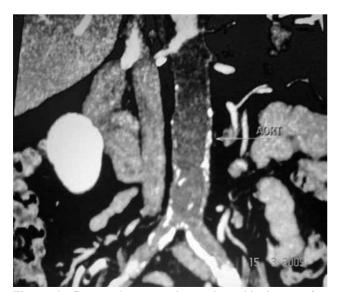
Computed tomography angiographic image of a suprarenal aortic occlusion.
